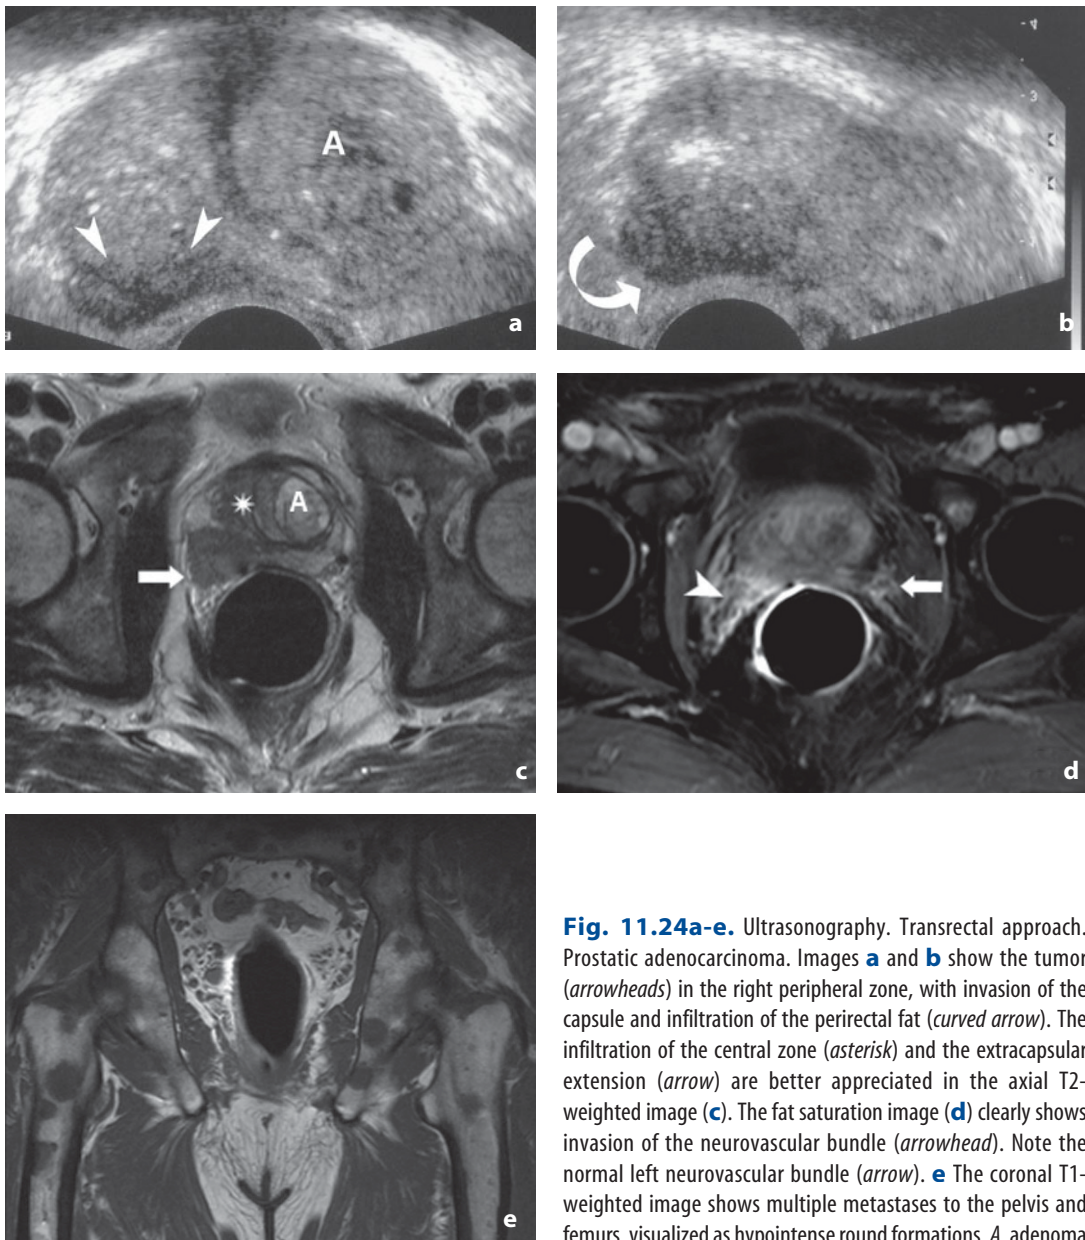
Ultrasonography. Transrectal approach. Prostatic adenocarcinoma. Images a and b show the tumor (*arrowheads*) in the right peripheral zone, with invasion of the capsule and infiltration of the perirectal fat (*curved arrow*). The infiltration of the central zone (*asterisk*) and the extracapsular extension (*arrow*) are better appreciated in the axial T2-weighted image (c). The fat saturation image (d) clearly shows invasion of the neurovascular bundle (*arrowhead*). Note the normal left neurovascular bundle (*arrow*). e The coronal T1-weighted image shows multiple metastases to the pelvis and femurs, visualized as hypointense round formations. A, adenoma
